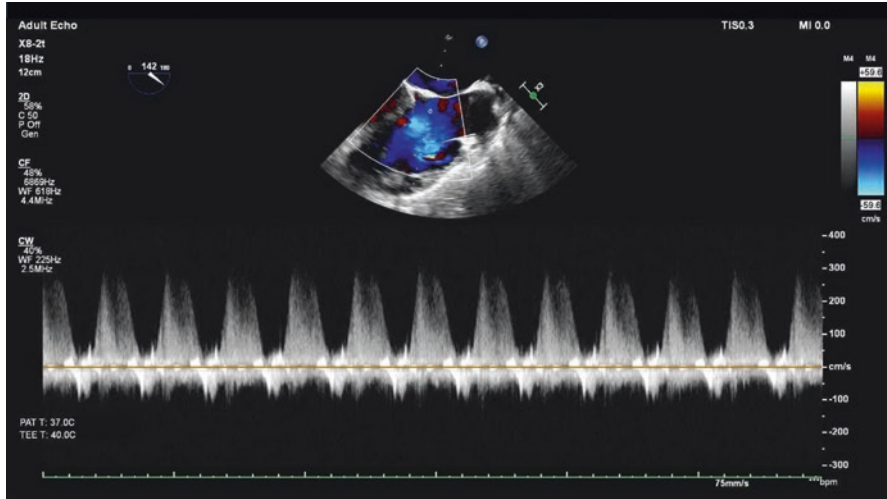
Continuous wave Doppler through the tricuspid valve from the modified bicaval view. This the tracing, one can measure the pressure gradient across the TV
